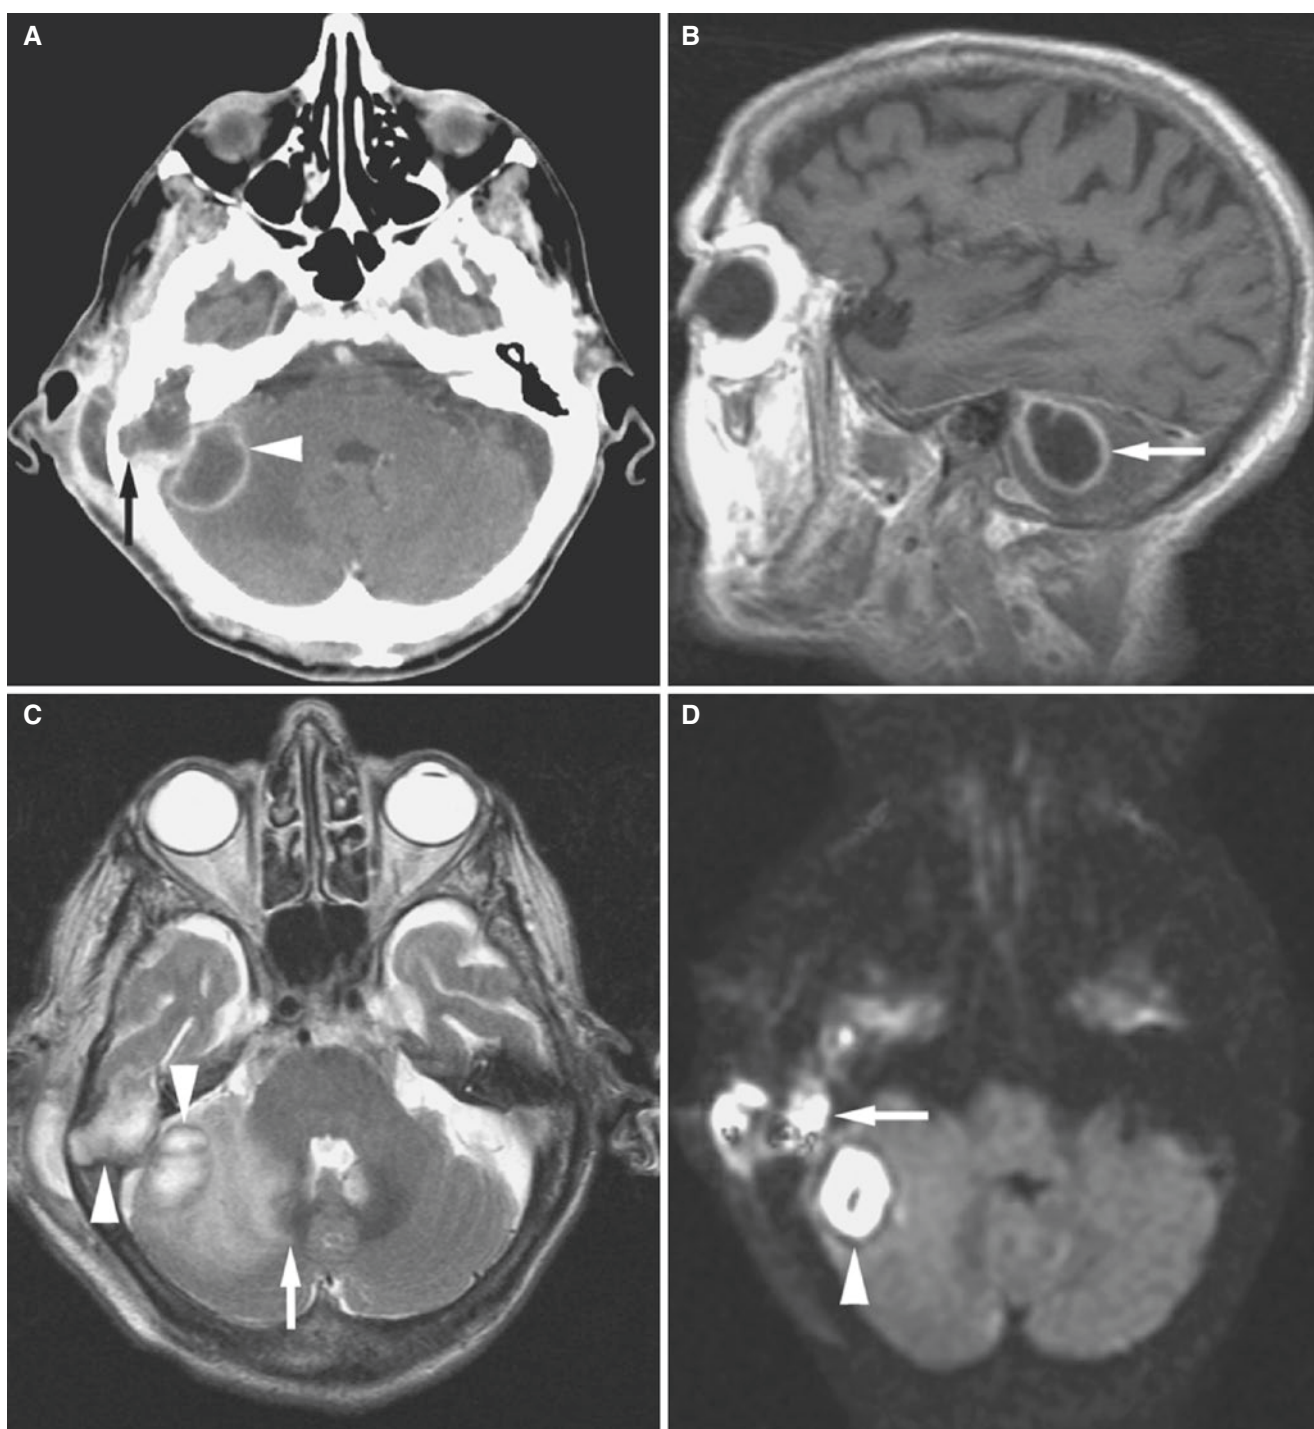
Mastoiditis with intracranial abscess; 94-year-old female presented with a 1-week history of fever and mental status change. Patient treated with antibiotics for two episodes of right otitis media. (A) Post-contrast axial CT image demonstrates right mastoiditis with erosion of right petrous temporal bone (*arrow*), involvement of adjacent dura, and ring-enhancing lesion in right cerebellar hemisphere indicating abscess (*arrowhead*). (B) Sagittal T1-weighted post-Gd MRI shows
